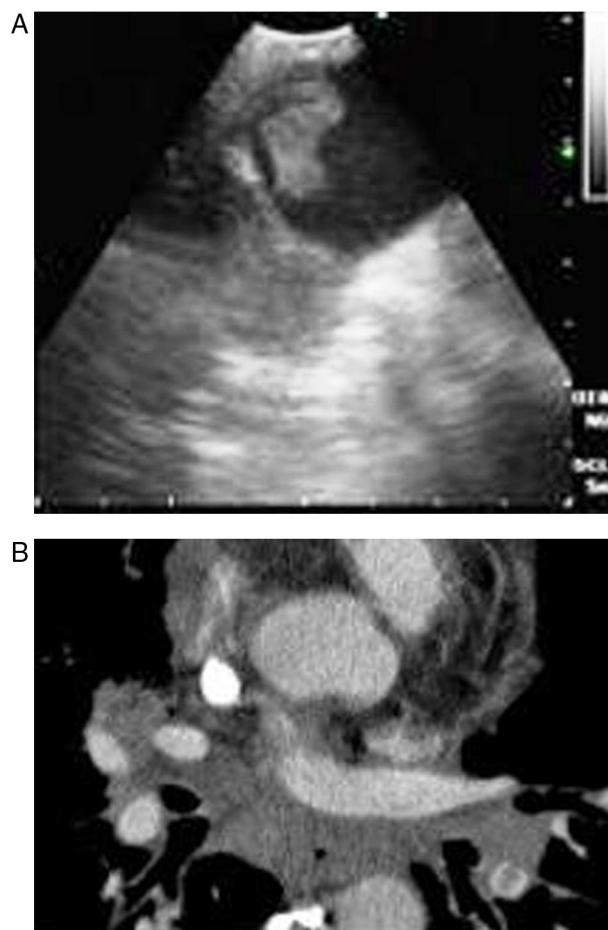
(A-B) Bilateral embolism in the central pulmonary artery in the chest CT scan.
